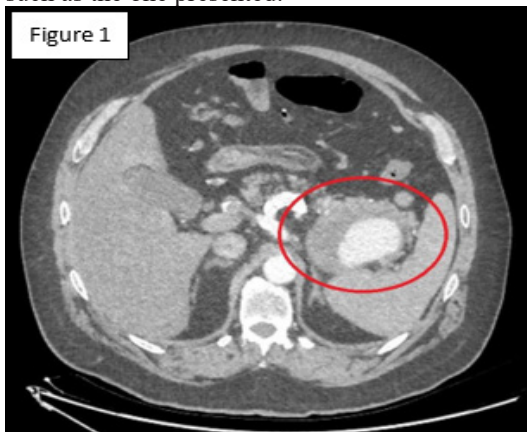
Radiological findings after performing an abdominal CT scan showing a giant splenic aneurysm with mural thrombus
